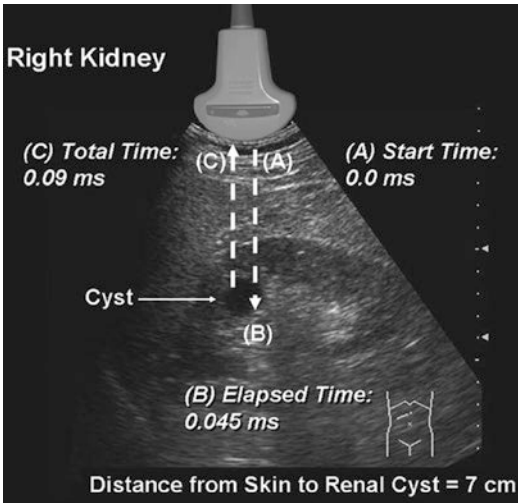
Ultrasound ranging depends on assumptions about the average velocity of ultrasound in human tissue to locate reflectors in the ultrasound field. The elapsed time from pulse transmission to reception of the same pulse by the transducer allows for determining the location of a reflector in the ultrasound field
